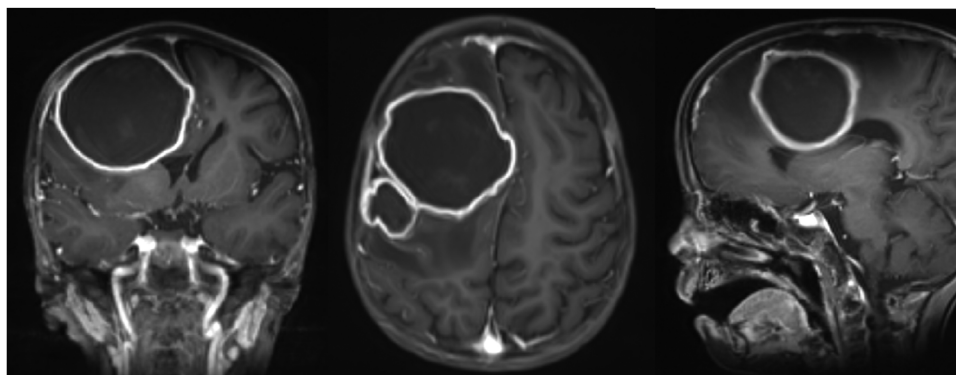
Cranial MRI Scan on day 80 of induction treatment.
